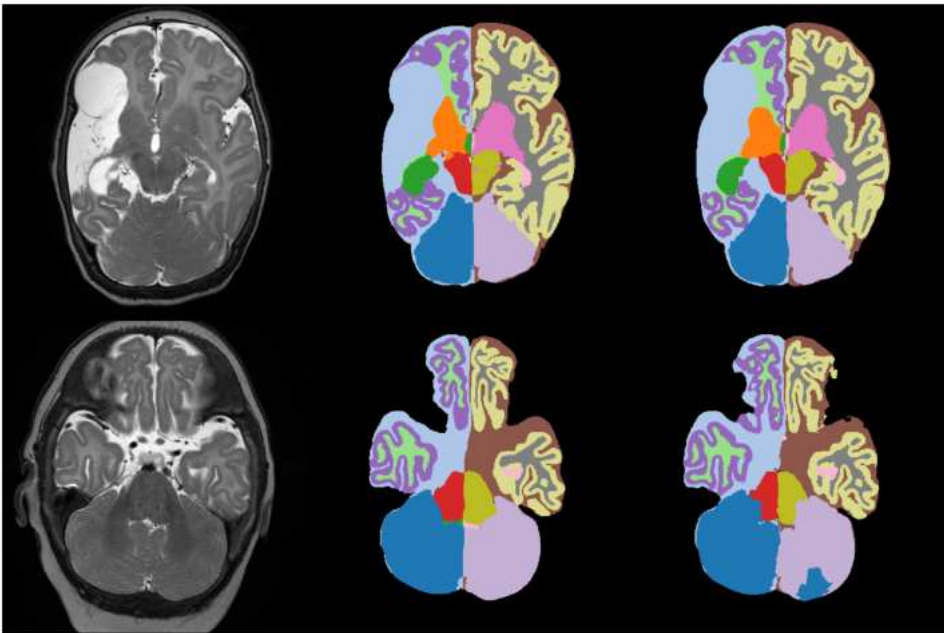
Example of brain tissue segmentations on follow-up scans for two patients (top and bottom row). From left to right: T2-weighted scan, reference segmentation and automatic segmentation. The top row shows a scan which was accurately segmented. The bottom row shows a scan on which the right cerebellum is incorrectly segmented.
